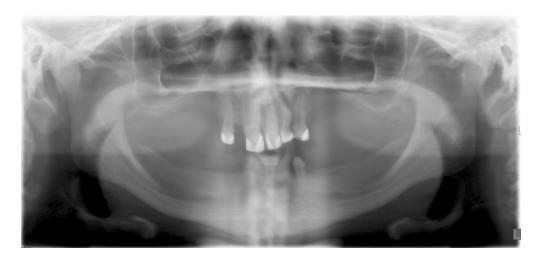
The initial panoramic x-ray image of the patient $97x45mm (300 \times 300 DPI)$
